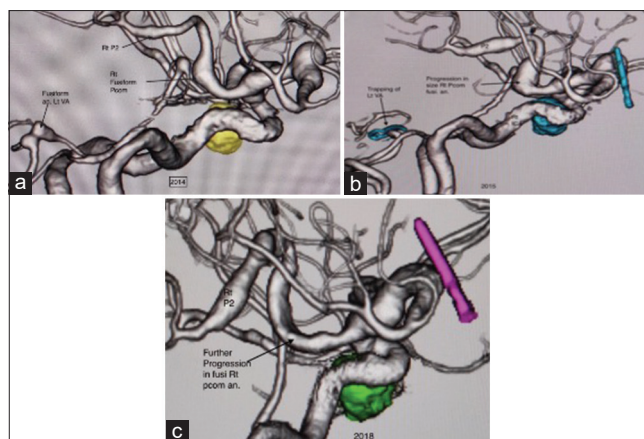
(a) Lateral view computed tomography angiography 2014 showing fusiform right posterior communicating artery segment up to P2 posterior cerebral artery segment with fusiform left vertebral artery aneurysm. (b) 2015 computed tomography angiography showing trapped segment of left vertebral artery. (c) In 2018 showing a further increase in size and extent of the dolichoectatic segment of right posterior communicating artery
